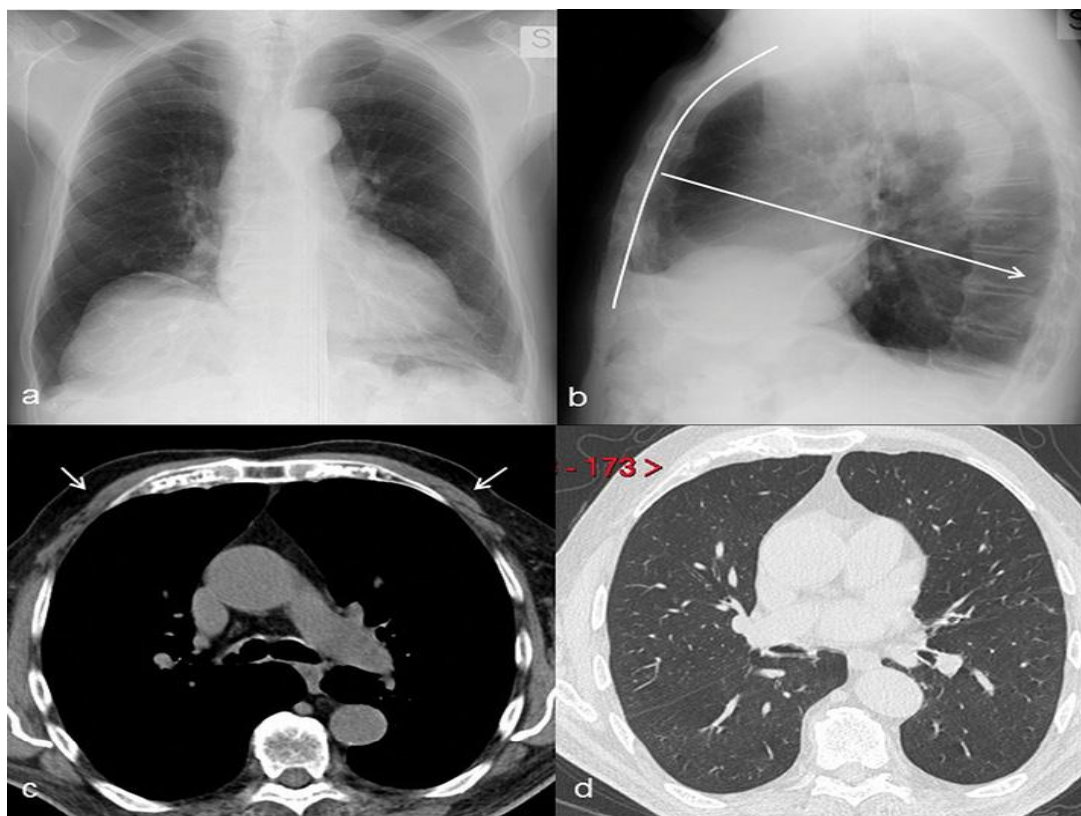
Chest imaging in elderly patients presents special considerations for radiologists. Above: Frontal (a) and lateral chest X-ray (b) of a 78-year-old man show a "barrel chest" deformity with increase in the antero-posterior diameter (white arrows in b) with an apparent increase in lung transparency and hyperlevation of the right hemidiaphragm. Subsequent CT scans show atrophy of pectoral muscles (white arrows in c) partially responsible for the hyperlucency of lung parenchyma. Signs of pulmonary emphysema are not on CT (d). Hyperlevation of the right hemidiaphragm is due to muscle dyskinesia.
